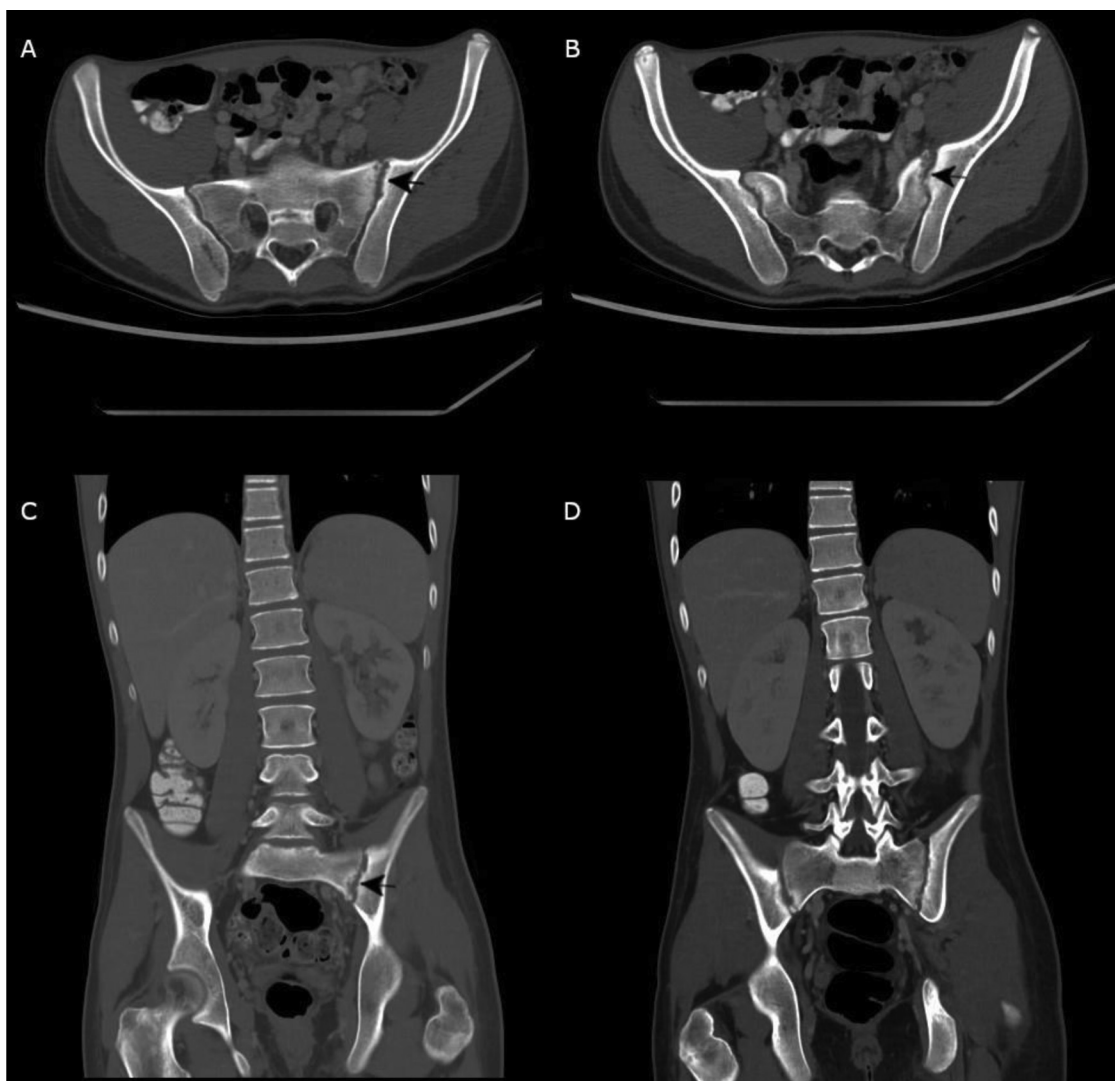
Computed tomography (CT) scan of abdomen and pelvis (bone windowed) showing subtle asymmetrical bony erosions and joint space widening at the left sacroiliac joint on the axial (A, B) and coronal (C, D) views.
